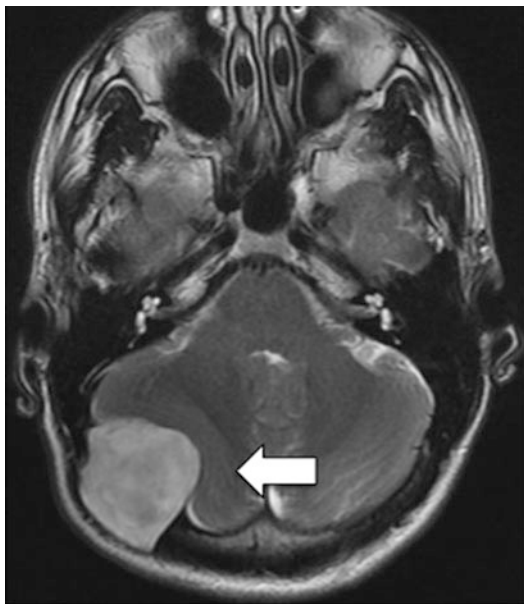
Occipital dermoid as demonstrated on axial T2-weighted MRI with posterior fossa intracranial extension
